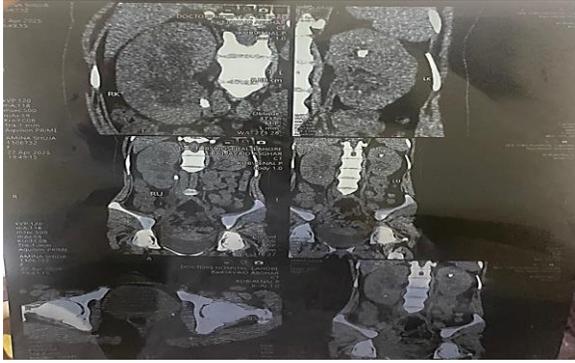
Report of CT-KUB and serum PTH (649)
